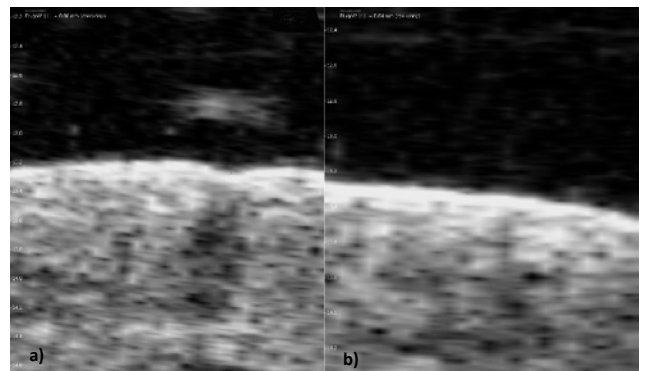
Ultrasound image of the control sample: a) before the treatment session, b) after the sixth treatment. Thickness of the dermis on the neck
